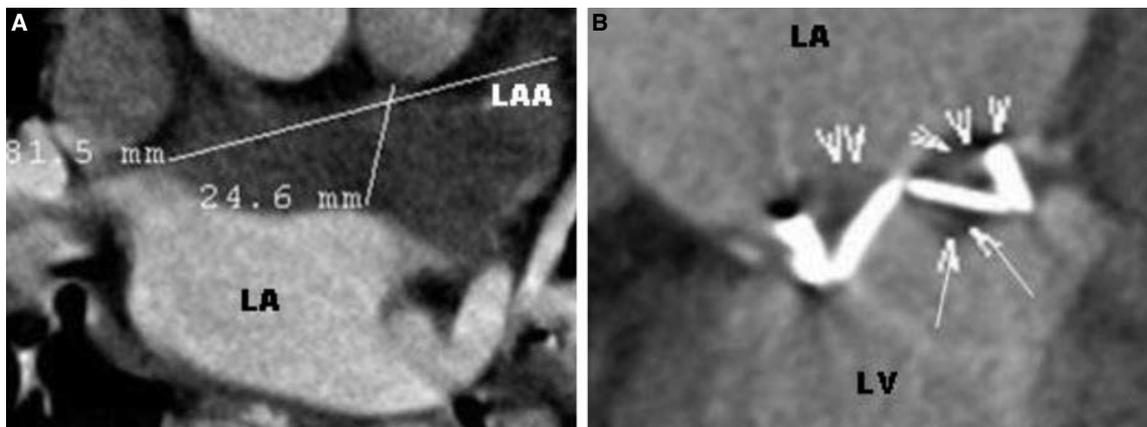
(A, B) Multidetector computed tomography depicted the thrombus involving both atrial (arrows) and ventricular (arrowheads) aspects of the prosthesis. LA: Left atrium; LV: Left ventricle.
